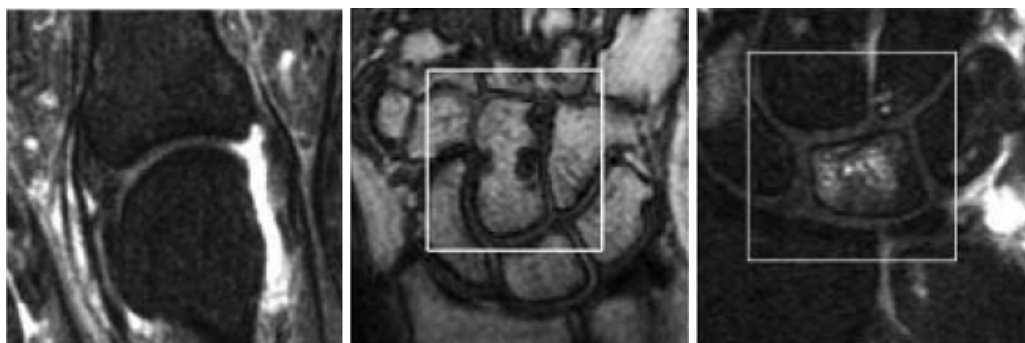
Example images of RA MRI features [20]. Left: bright edge indicates synovitis of an MCP joint. Middle: bone erosion (dark spot) of the capitate in the wrist. Right: high signal inside the bone indicates BME of the lunate. Note inflammatory lesions are best seen on contrast-enhanced MRI (left and right), whereas erosive features are best captured by pre-contrast T1 MRI (middle). See Figure 1.5 for bone anatomy of the hand.
